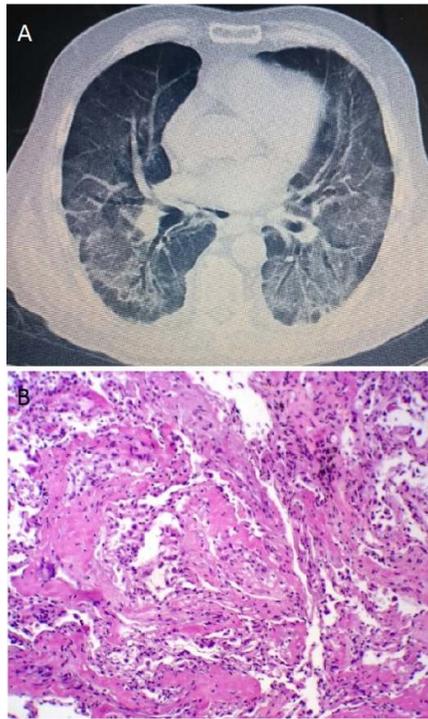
A, chest CT showed ground glass images in both lungs. B, biopsy obtained by bronchoscopy revealing hyalinized focal lung fibrosis with hyperplasia of type II pneumocytes
